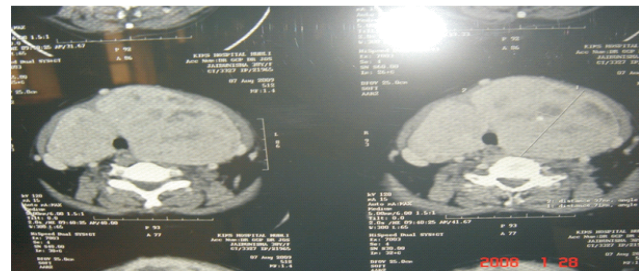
CT image at C7 level.
